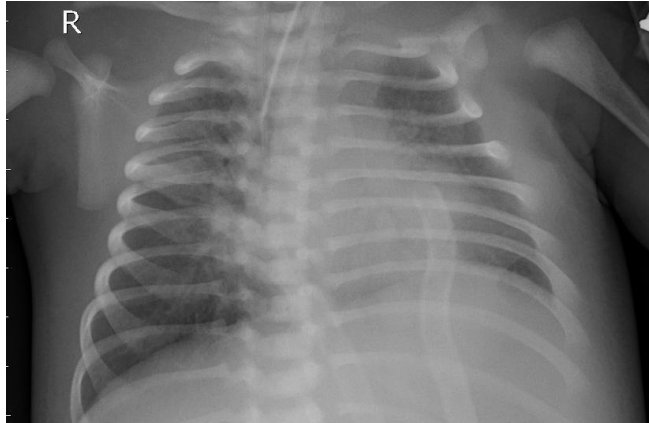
Chest X-ray image of a sick person because of bacteria shown in Figure 1a.
